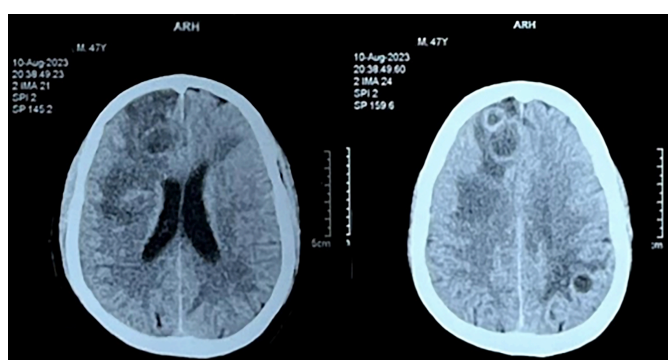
CT scan of the brain showing multiple well-defined lesions suggestive of space-occupying lesions with surrounding vasogenic oedema.
